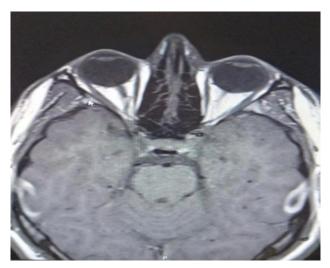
The Magnetic resonance imaging (MRI) scan shows a narrow stalk that represents the presumed left optic nerve in the orbit.
